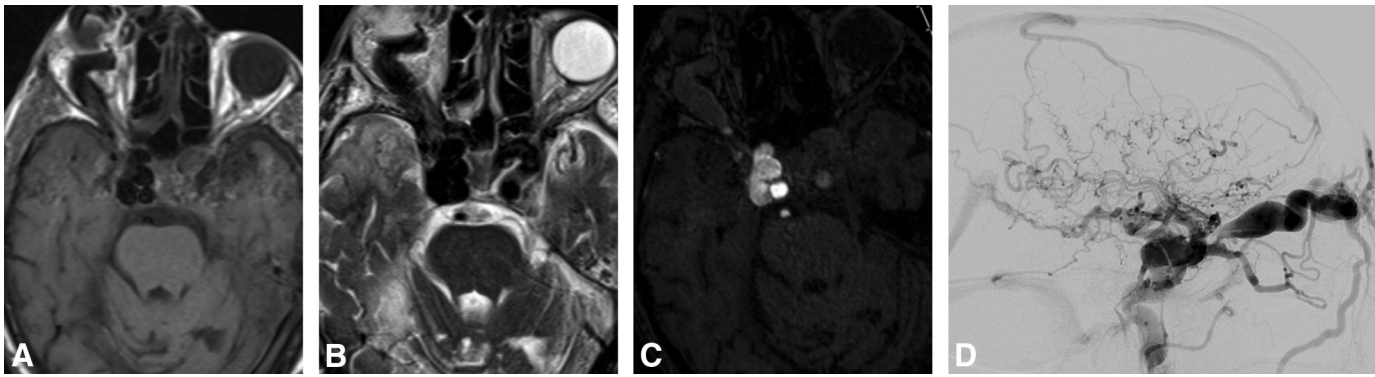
CCF. Axial T1WI (A), T2WI (B), MRA (C), and cerebral angiogram (D) of a CCF. An 88-year-old man admitted for status epilepticus. MR imaging of the brain (A–C) demonstrates a markedly enlarged right cavernous segment of the internal carotid artery with associated severe enlargement of the right superior ophthalmic vein. There also is arterial flow noted within the right cavernous sinus on the MRA (C) of the brain. There is marked venous congestion along the right cortical veins with associated venous hypertension and cortical hyperintensity on T2 (B), which is likely the cause of the seizure in this patient. Cerebral angiogram with right internal carotid artery injection with a subtracted view demonstrates early filling of the right cavernous sinus, with antegrade flow to the right superior ophthalmic vein toward the facial vein, along with additional venous reflux to the cortical vein of the right hemisphere, with drainage toward the superior sagittal sinus and the straight sinus.
